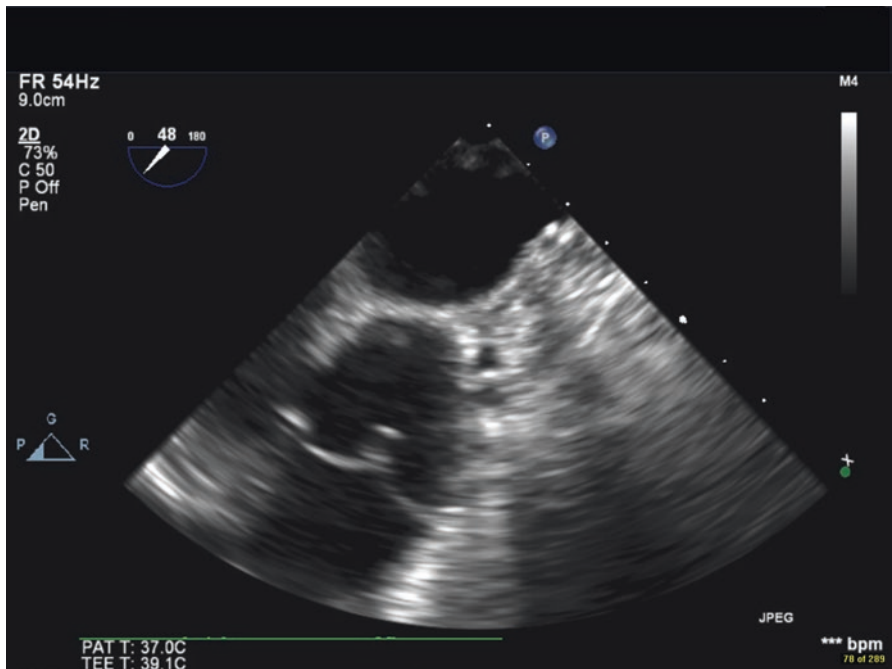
Pulmonic valve visualized from the UE aortic arch SAX view. From here, one can measure velocities and gradients across the PV due to excellent Doppler alignment
